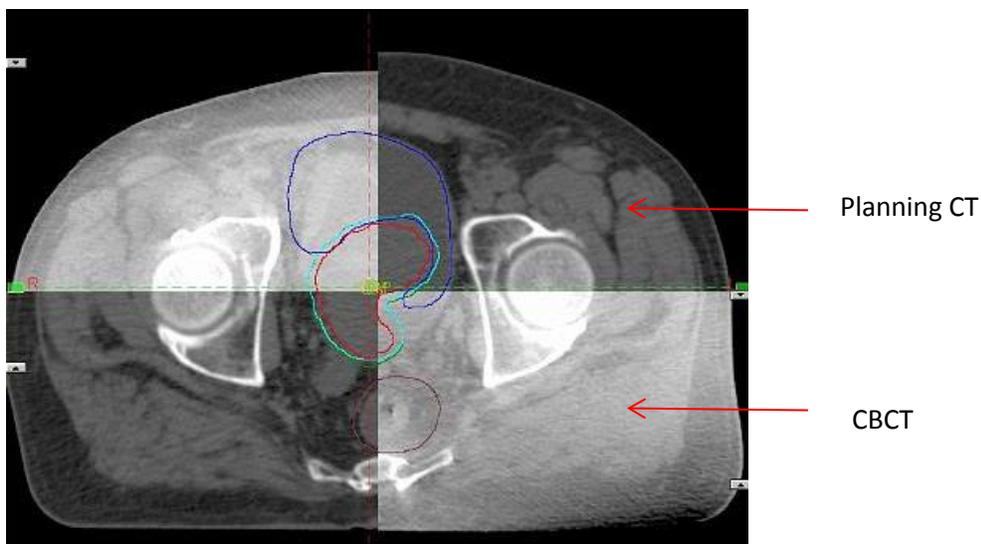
Cone beam computed tomography and planning computed tomography fusion and alignment. An overlay technique can be used to verify patient’s alignment compared to plan. Adapted from Google Images (2016a).
